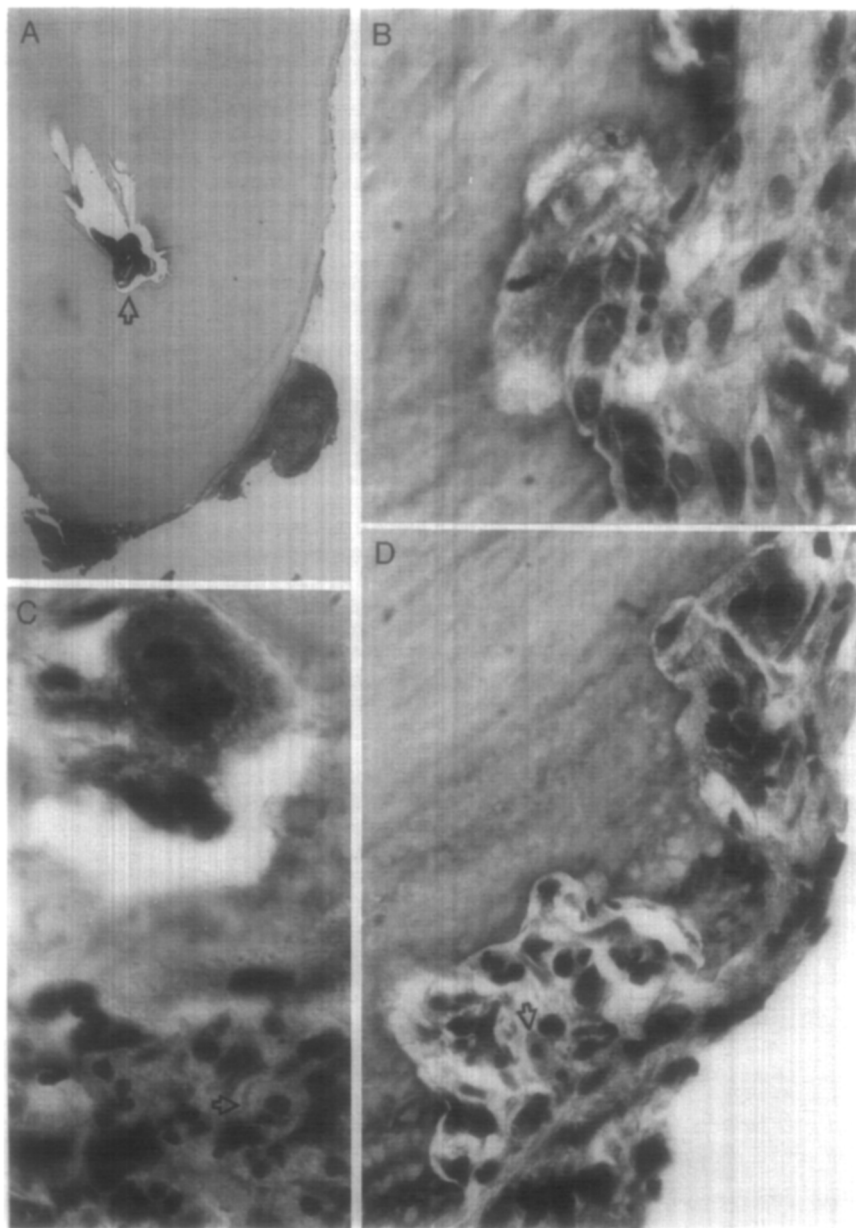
Case 214 (same as in Fig. 1). *A*, Mesial root with attached granuloma and lacuna along the root surface; remaining endodontic material in part of the canal visible in this section (*arrow*). *B*, Resorption of periapical root with clastlike cell in lacuna and on its margin. *C*, Clastlike cell in lacuna in apical area. Attached granuloma with neutrophilic leukocytes, foam cells (*arrow*), and lymphocytes. *D*, Upper lacuna with clastlike cell in periapical region; lower lacuna with apposition and inflammatory cells. Mast cell (*arrow*), also shown in Fig. 4, *E*. (Original magnifications: *A*, $\times 16$; *B*, $\times 1,000$; *C* and *D*, $\times 630$.)
